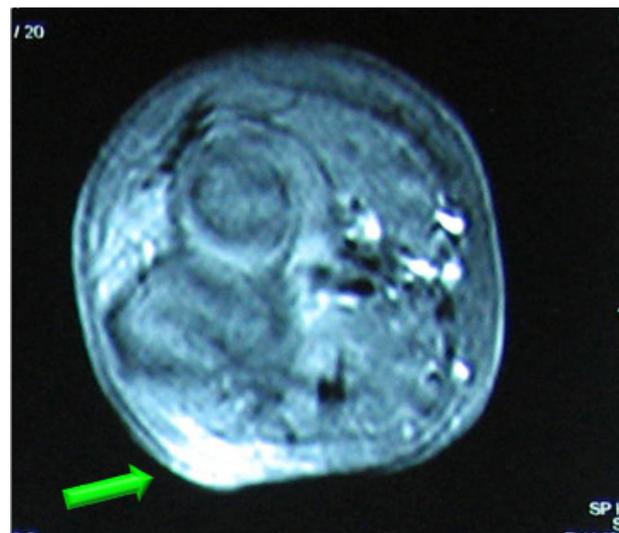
Magnetic resonance imaging (T2) view of the tumor which was taking up contrast agent, in close proximity to the olecranon and the ulnar nerve.
